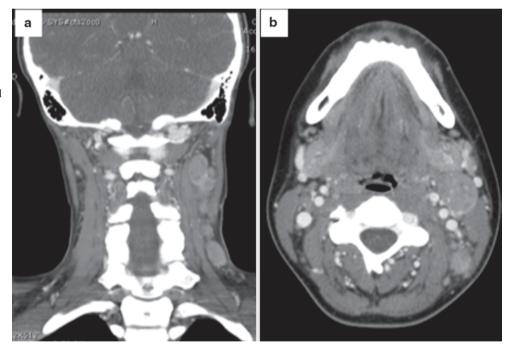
Postcontrast coronal (a) and axial (b) CT images of neck soft tissues of the patient described in Fig. 17.1. There is significant heterogeneous lymphadenopathy in the left cervical chain, left retropharyngeal space, and posterior triangle. The largest node measures 3×2.2 cm
